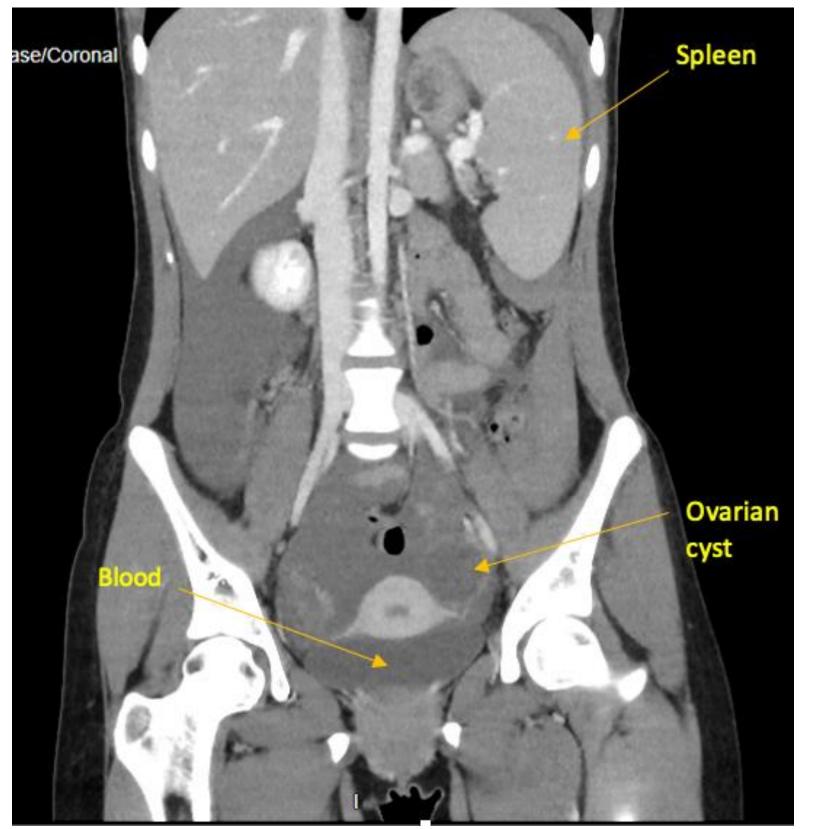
CT showing haemoperitoneum, ovarian cyst and intact spleen
